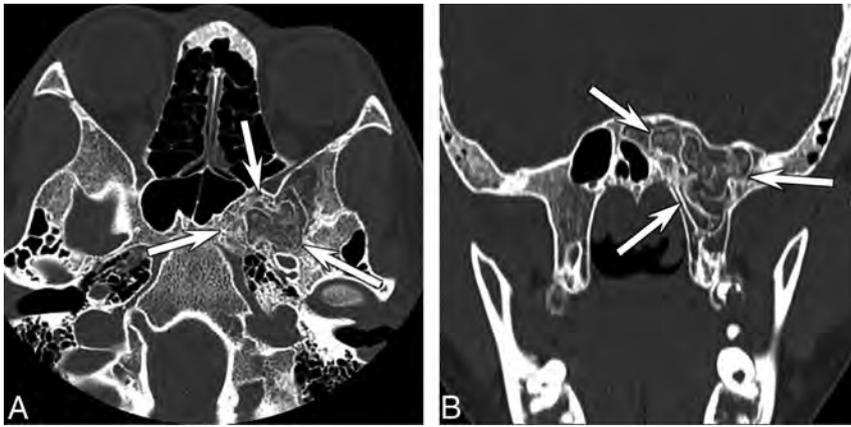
Axial (A) and sagittal (B) contrast-enhanced CT images show a nonexpansile lesion (arrows) located at a normal left sphenoid sinus pneumatization site with a thin cortical margin, internal fatty content, and curvilinear internal calcifications. This is the characteristic appearance and location for arrested pneumatization of the sphenoid sinus.
